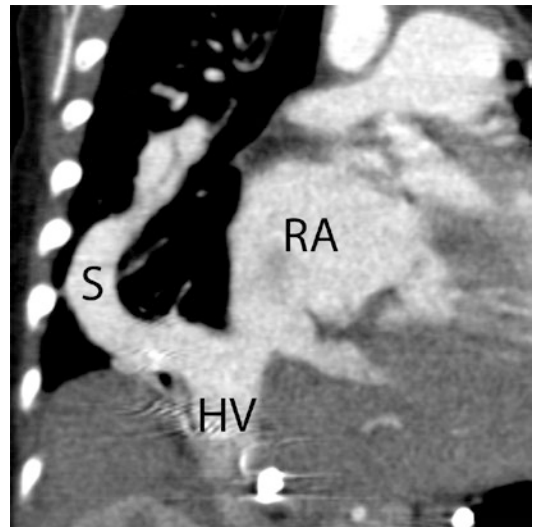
CT, Scimitar syndrome. The computed tomography contrast-enhanced angiogram shows complete anomalous connection of the entire right lung via a scimitar vein to the suprahepatic inferior vena cava. HV hepatic vein, RA right atrium, S scimitar vein
